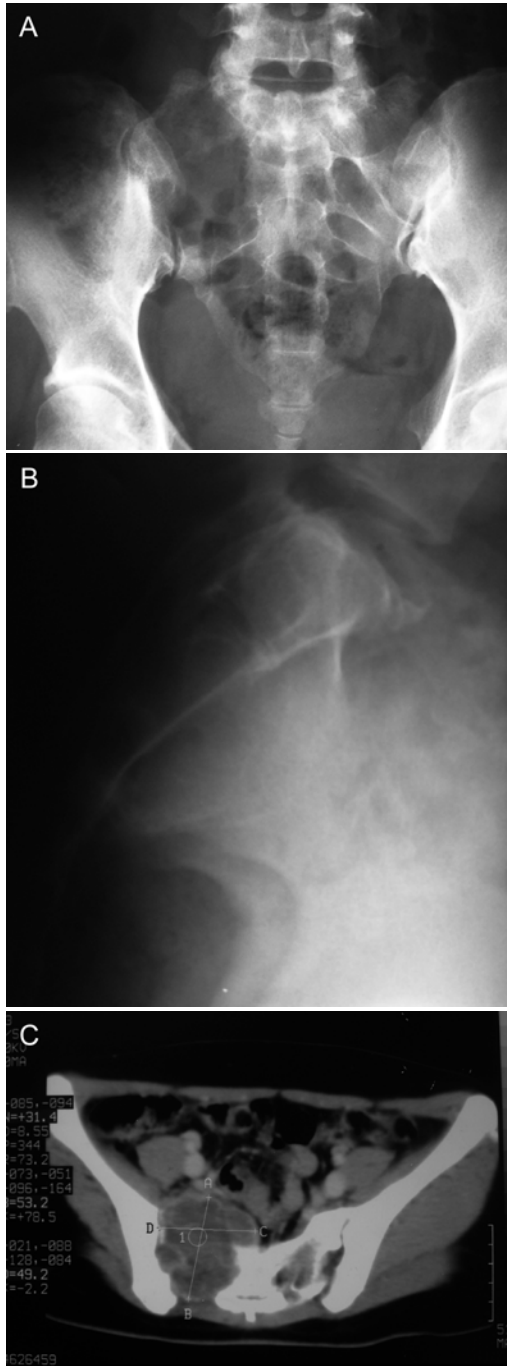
Giant cell tumor at the right sacrum. (A) an antero-posterior (AP) radiograph of patient showed an osteolytic lesion in the lateral part of the right upper sacrum. (B) lateral plain radiographs of sacrum revealed soft tissue mass at anterior aspect of sacrum. (C) CT scans demonstrated the extent of soft tissue projection, and osteolytic lesion at the right sacrum
